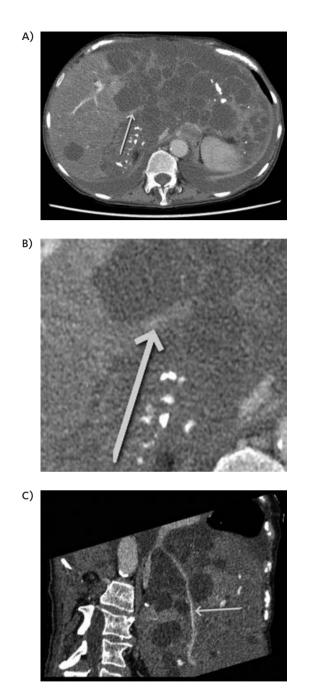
Panel A: CT-scan of chest and abdomen with intravenous contrast (transverse plane). Panel B: Magnification of the image in panel A. Panel C: In this more detailed reconstruction, the scan is centered on the right hepatic vein (arrow) with other structures warped around it. This shows that there was still some residual blood flow in the right hepatic vein, draining into the inferior caval vein.
